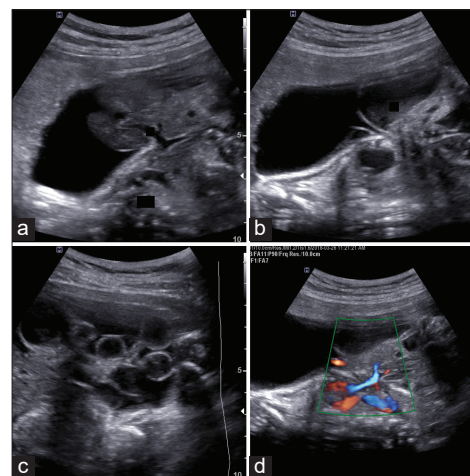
Antenatal ultrasound scan showing fetus with a congenital abnormality
